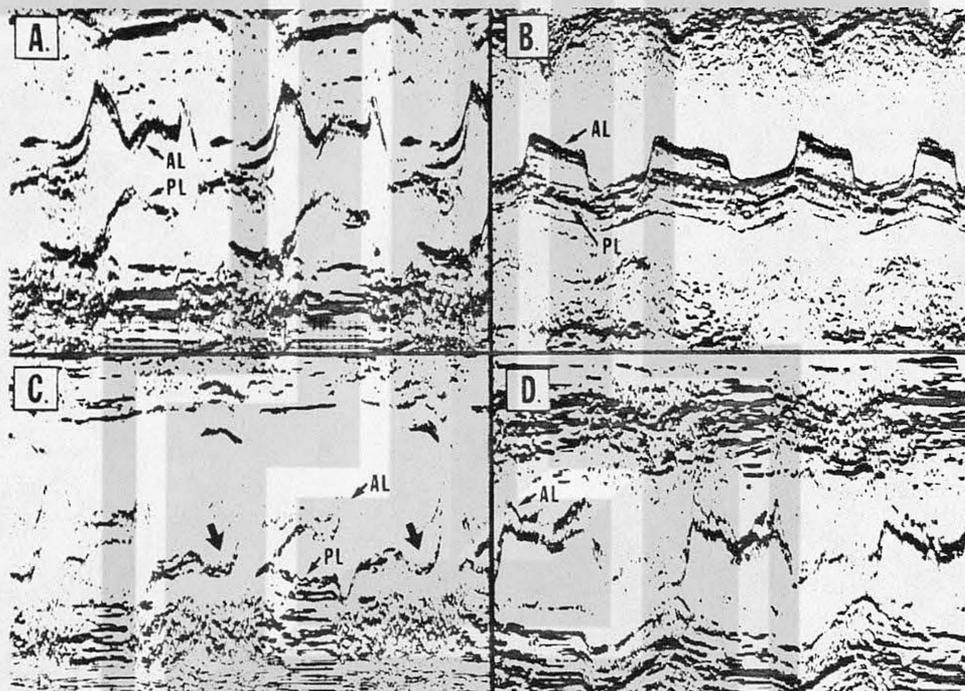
Echocardiograms.
